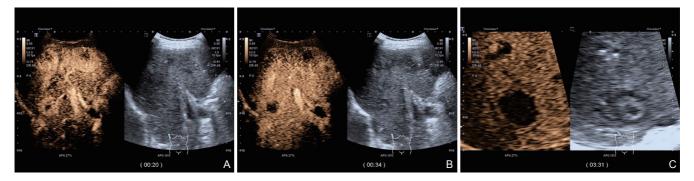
Hepatic contrast-enhanced ultrasound. (A) Masses showed rapid peripheral centripetal enhancement during the early arterial phase (20 seconds); (B) Masses began to fade during the arterial phase (34 seconds); (C) Masses were washed out during portal venous and delayed phases (211 seconds).
